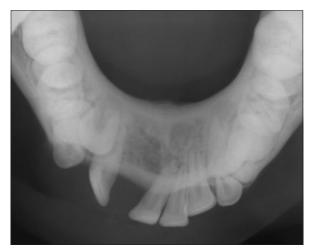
Radiograph showing the lesion in mandible.
